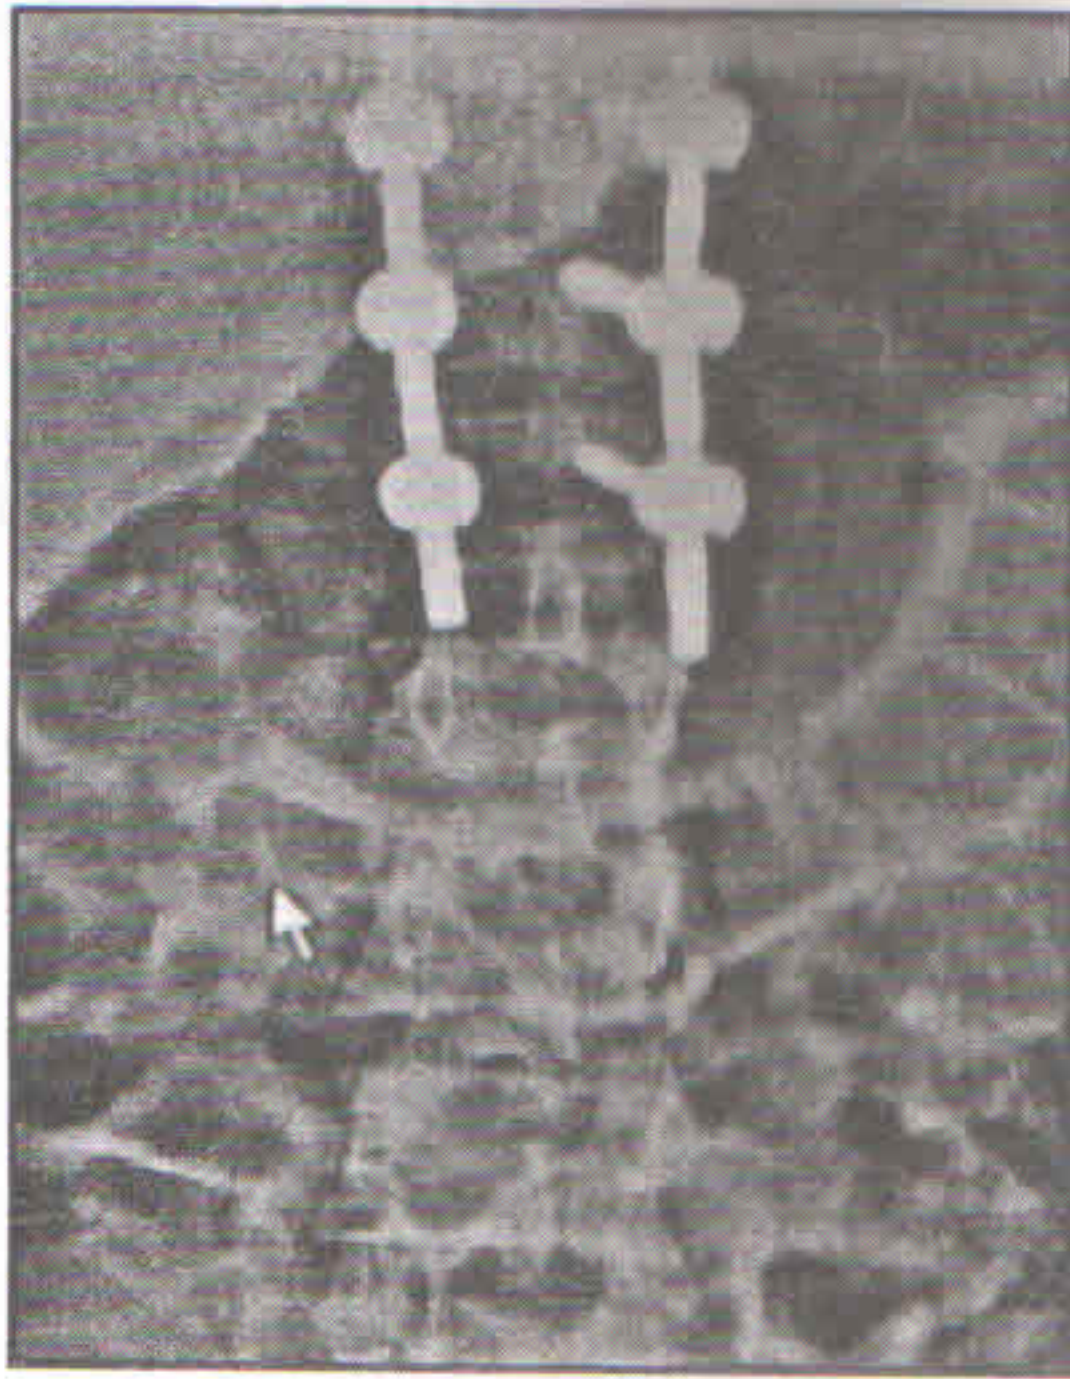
(c) and 1 (d) : Immediate post operative X-ray
